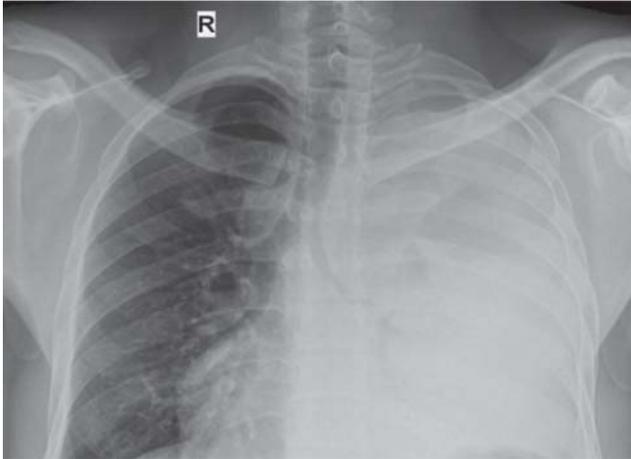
Chest radiograph (postero-anterior view) showing an opaque left hemithorax with obliteration of the left cardiophrenic and costophrenic angles and shift of the mediastinum to the contra-lateral side.
